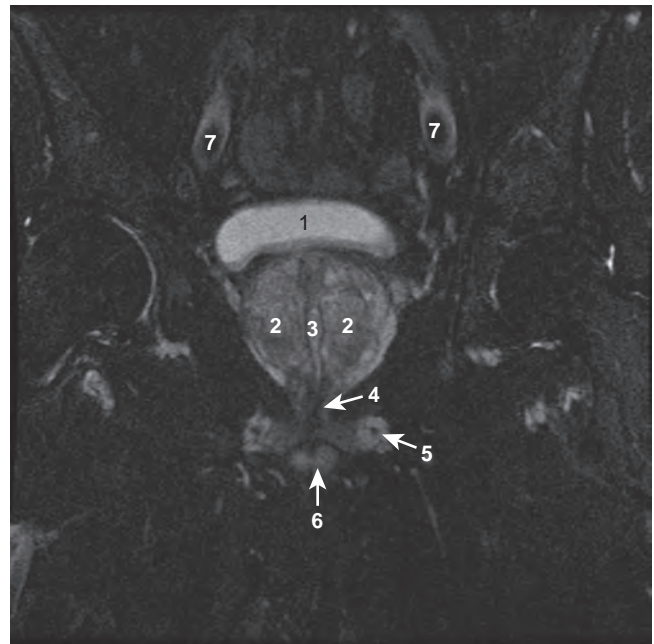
Axial T2-weighted magnetic resonance image of the male pelvis through the prostate gland and adjacent structures. 1, Urinary bladder; 2, lateral lobes of prostate; 3, verumontanum; 4, striated urethral sphincter; 5, inferior pubic ramus; 6, corpus spongiosum in cross section; 7, external iliac artery.
